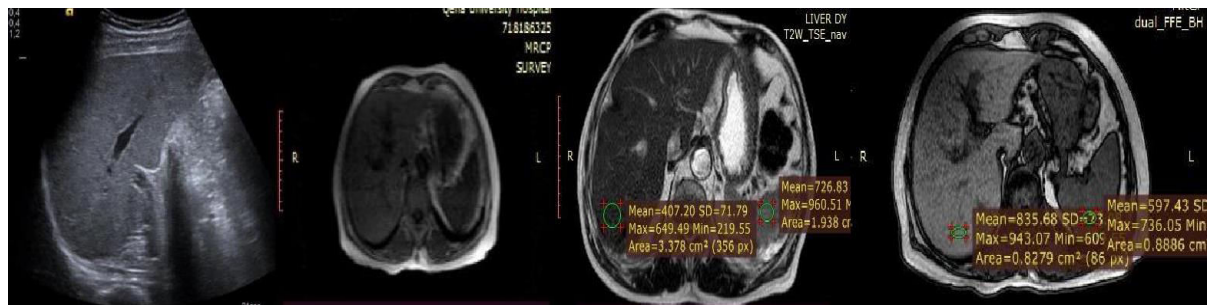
A 40-year-old non-diabetic female patient whose BMI was 24.7 kg/m² presented with upper abdominal pain.. Her liver enzymes were normal , SGPT= 22 U/L, SGOT=21 U/L, total bilirubin 0.38 mg/dl. Abdominal ultrasound showed diffuse fatty liver infiltration grade II. MRI showed Mildly hyper intense signals on T1, Hypo intense signals on both T2, and out phase With Liver Steatosis \pm 23.4
